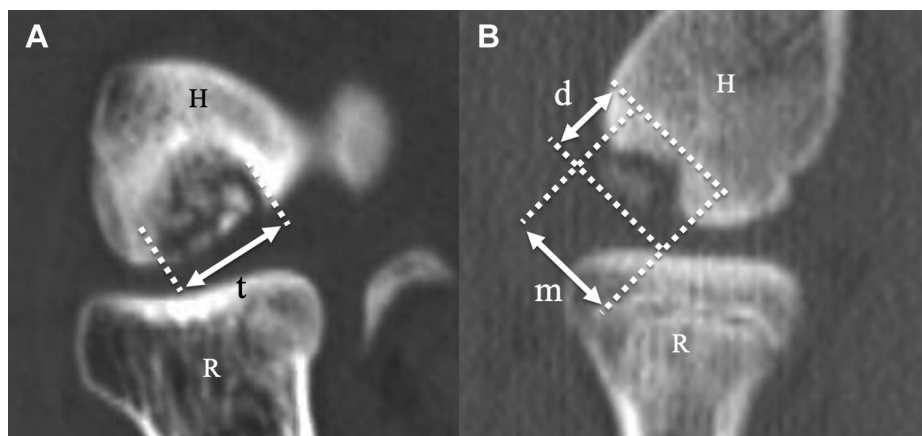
(A) Coronal CT image of the elbow; “t” indicates the transverse diameter of the osteochondral fragment. (B) Sagittal CT image of the elbow; “m” indicates the major diameter, “d” indicates the depth. CT, Computed tomography; H, Humerus; R, Radius.
